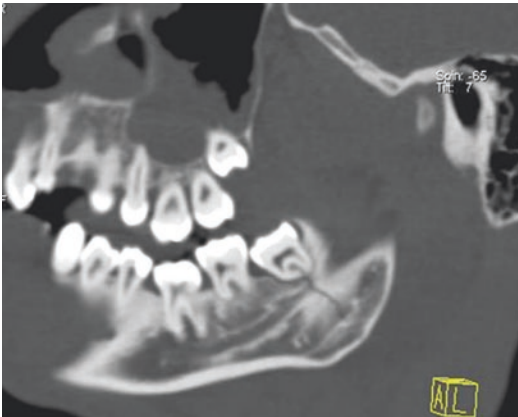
CT sagittal reformation showing a linear non-displaced fracture of the mandibular angle, entering the last molar tooth socket
